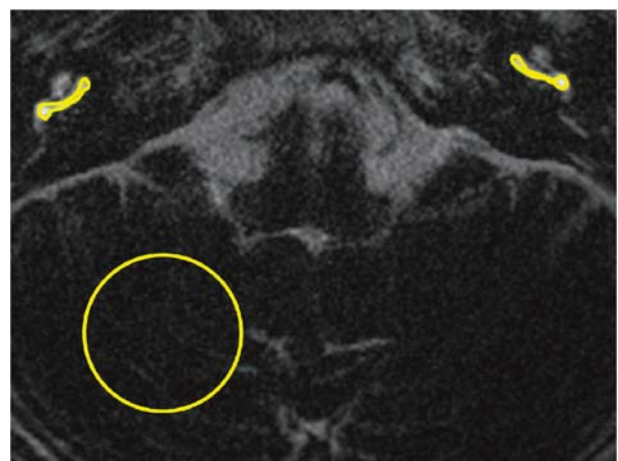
An example of the region of interest (ROI) on a contrast-enhanced hT(2)W-3D-FLAIR image. The ROI for cochlear fluid signal intensity (SI) measurement was drawn manually around the basal turn of the cochlea. The circular ROI for SI measurement of the cerebellum was positioned in the most artifact-free area of the cerebellum. Finally, we compared the SI ratio between the basal turn of the cochlea and the cerebellum.
